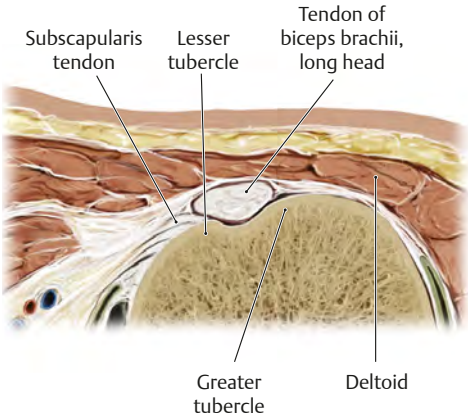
Diagnostic ultrasound of the anterior region of the left shoulder
